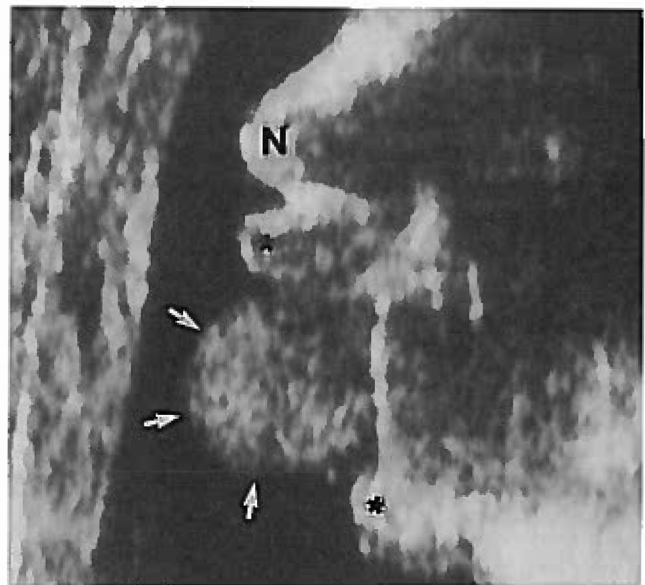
Midsagittal sonogram of the lower face shows the mass (arrows) protruding from the open mouth. N, nose; asterisks indicate lips.
